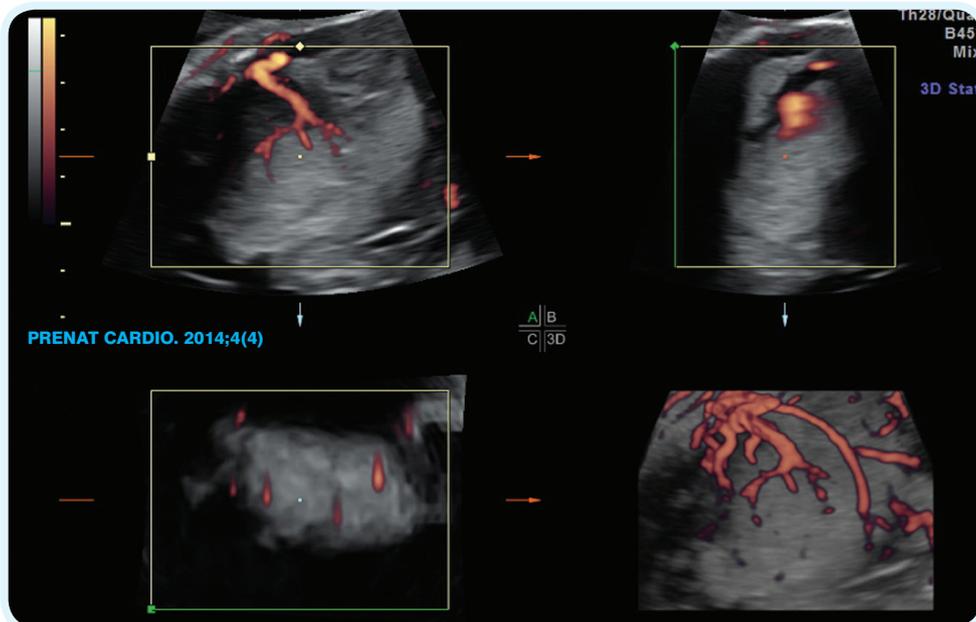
Increased vascularity of the fetal brain in power angio Doppler
